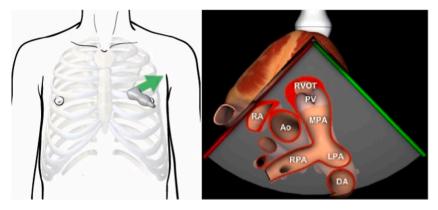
Parasternal short axis view: Pulmonary Artery Bifurcation (Image reproduced with permission from http://pie.med.utoronto.ca/TTE).
